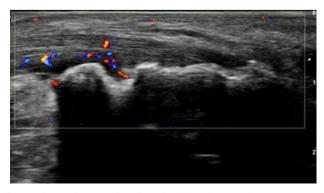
Achilles tendon with cortical and tendon Doppler signal.
